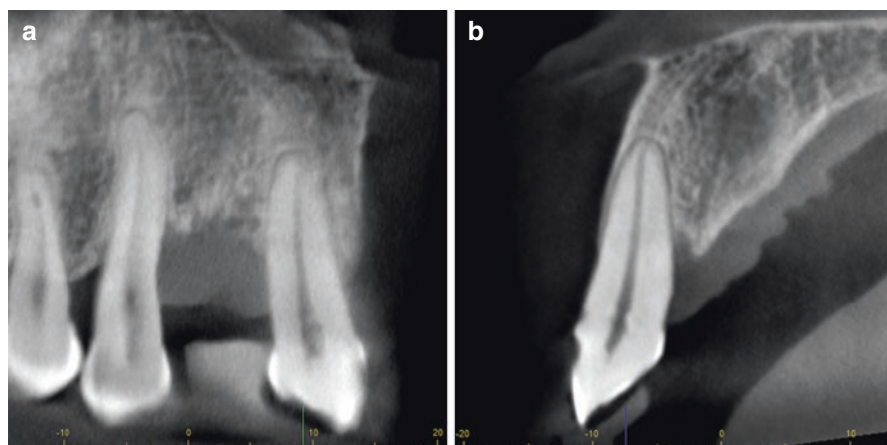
CBCT images of teeth adjacent to the edentulous site of #7 demonstrating marked loss of bony attachment. (a) Oblique coronal view and (b) cross-sectional view of tooth #8
